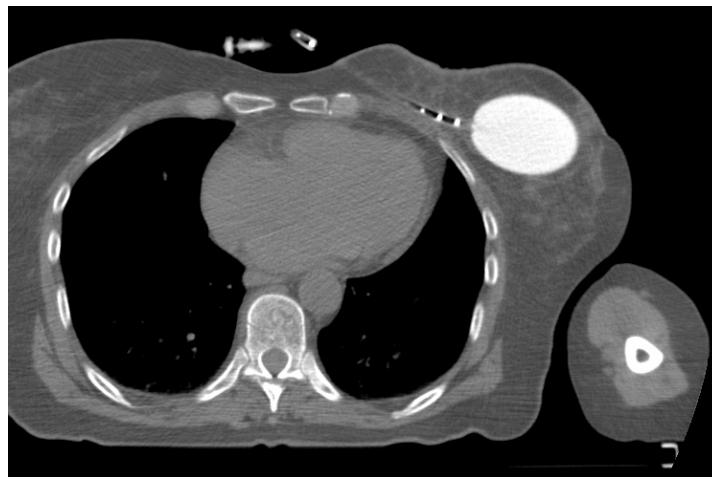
Patient CT image of implanted MammoSite device.
